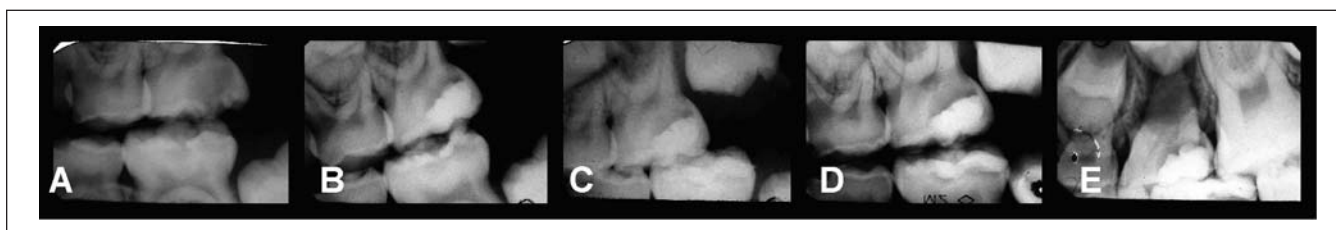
Radiographic evaluation of an upper second primary molar that received indirect pulp treatment with a self-etching primer on the remaining carious dentin. The treatment was considered a failure outcome after 2 years. Preoperative (A), postoperative (B), 6 months (C), 12 months (D) and 24 months (E) of radiographic follow-up.
